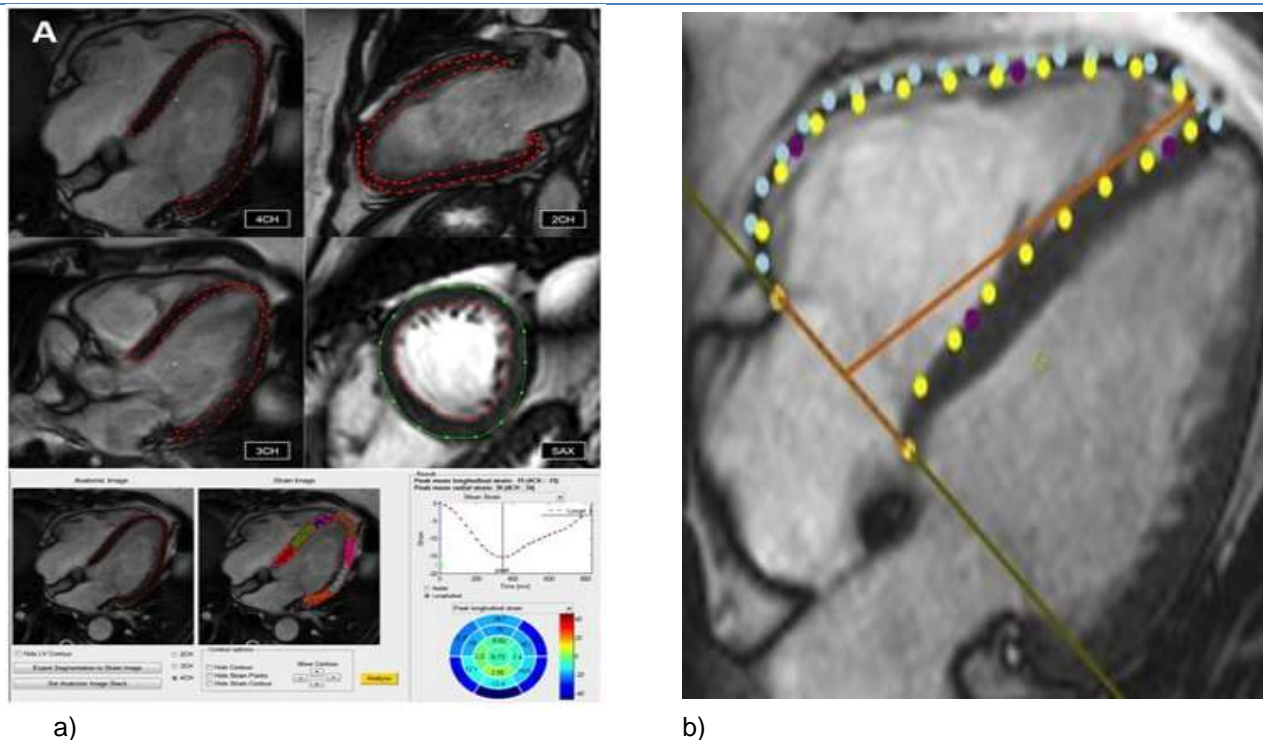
FT-CMR Myocardial strain is measured with Feature-tracking cardiac magnetic resonance imaging of LV, a) and RV, b) which are used for the analysis of myocardial segmentations and global longitudinal strains. A four-chamber view is called a 4CH; a two-chamber view is called a 2CH and a three-chamber view is called a 3CH.
